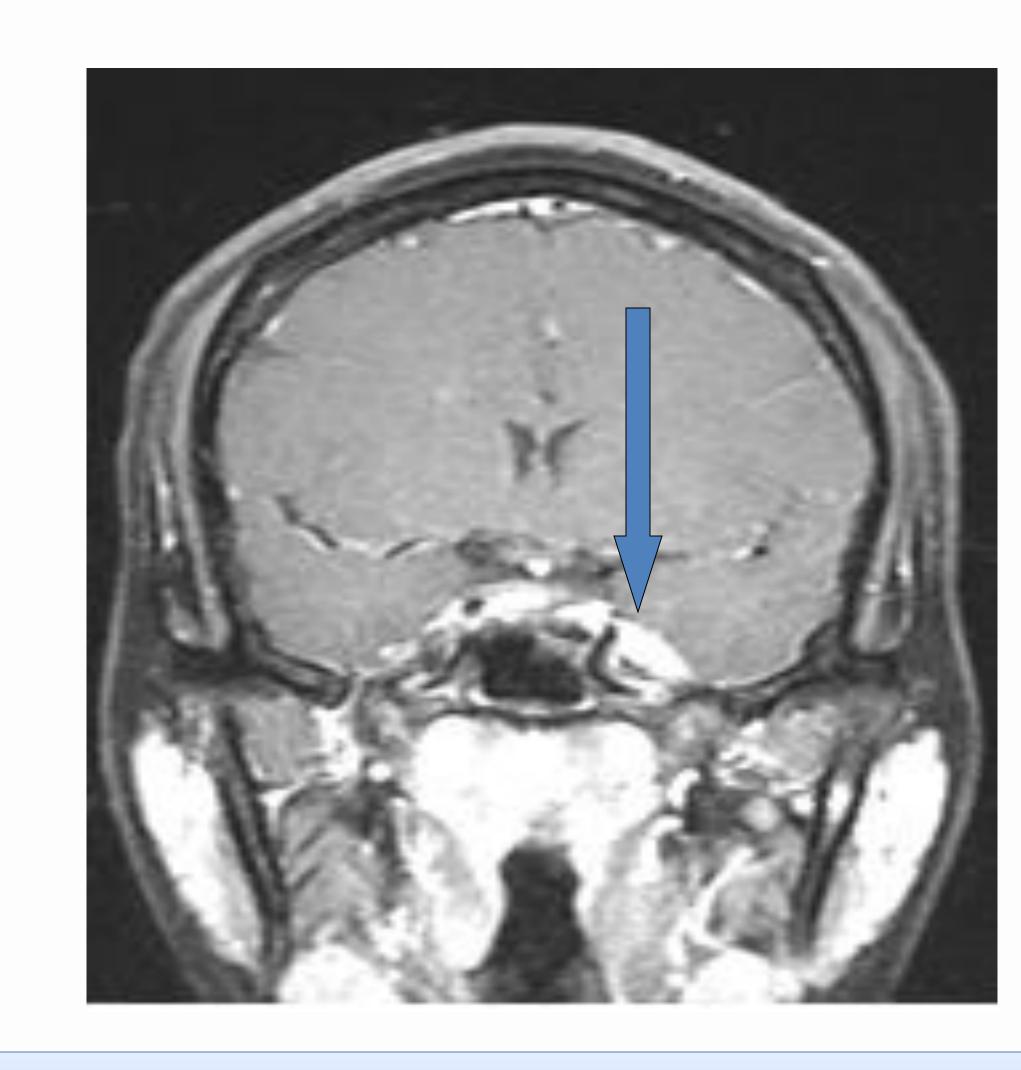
MRI T1 with gadolinium showing an enhancing lesion in the region of Meckel's cave.
